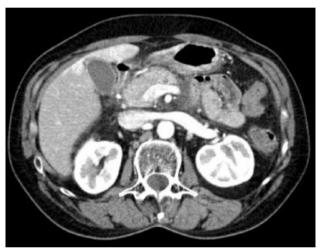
CT abdomen shows absence of pancreatic body and tail
